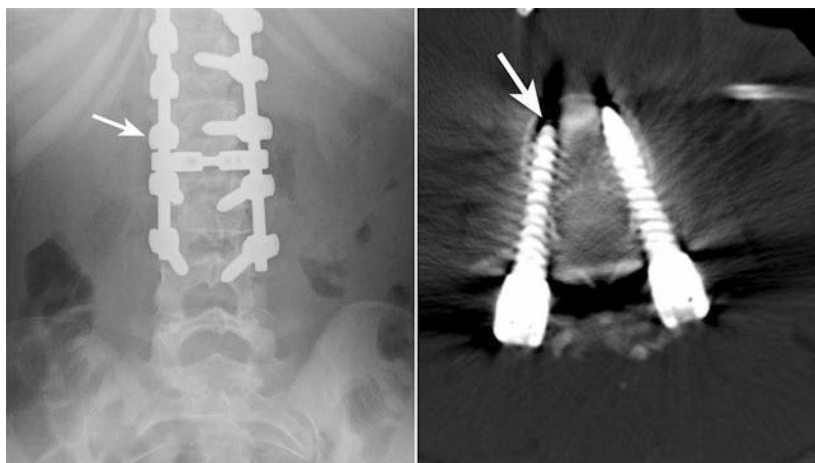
Radiographic film (left) showing a lateral misplacement denoted by the arrow, with the computed tomographic scan (right) showing a normal screw placement, denoted by the arrow.
